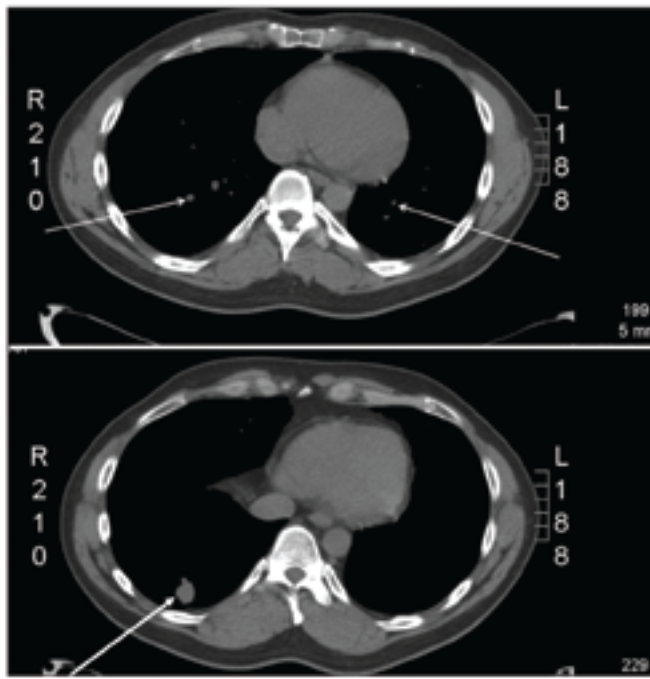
Computed tomogram of the patient's chest showing nodular soft-tissue densities (arrows), with the largest (lower panel) in the anterior basal region of the lower lobe with a feeding vessel of 8–10 mm in diameter.
